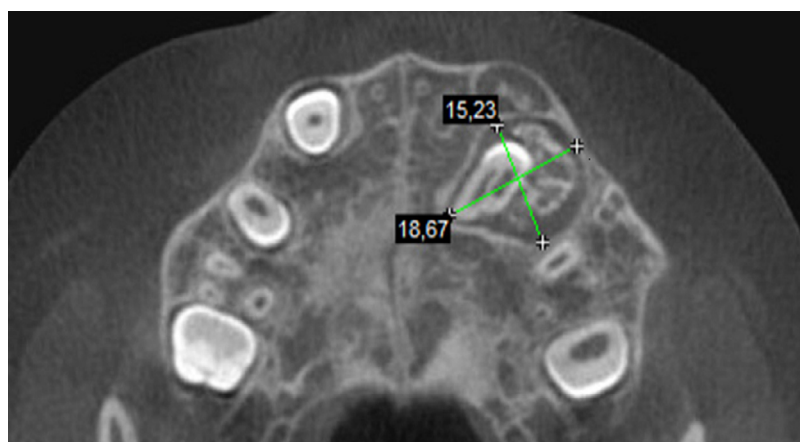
Axial view computed tomography (CT) scan showing unilocular and well-delimited hypodense area with hyperdense foci associated with nonerupted primary tooth #63.
